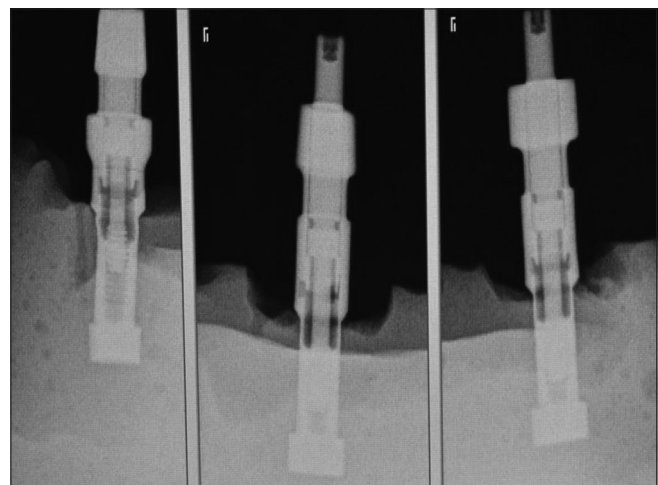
IOPA of the conventional implant open tray impression after pouring the cast. IOPA: Intra Oral Periapical radiographs
